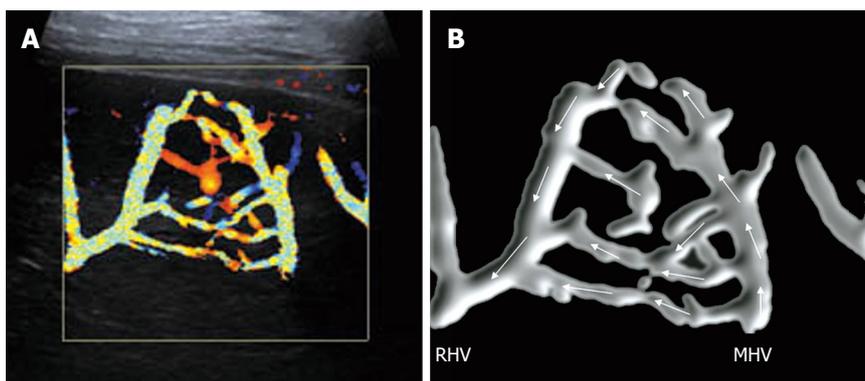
Color Doppler ultrasonography (A) and its sketch (B) showing MHV tributaries draining into the RHV via collaterals after thrombosis of vessel grafts on postoperative day 7 in a 32 years old male who received a right lobe graft from his wife.
